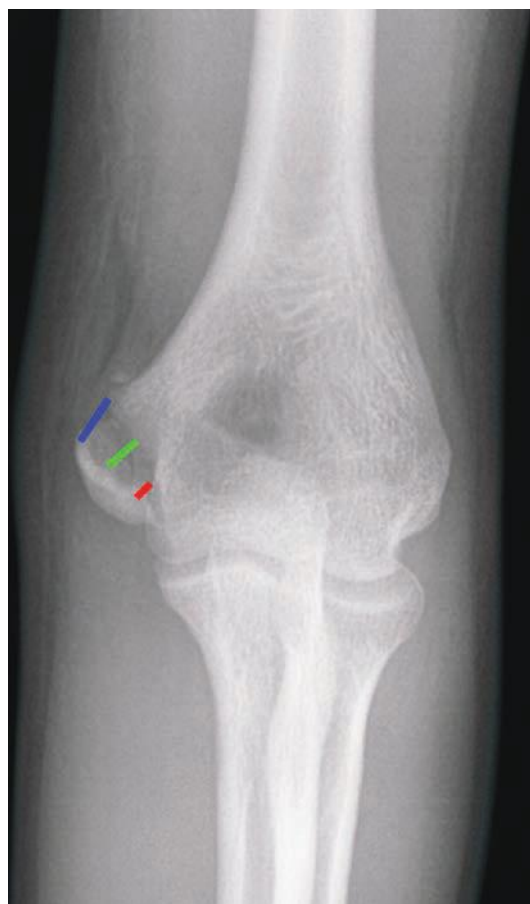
On anteroposterior radiograph of a left elbow with a medial epicondylar fracture, there are three different places where displacement could be measured. The red line represents 2 mm of displacement; the green line, 3 mm; and the blue line, 5 mm. (From Pappas N, Lawrence JT, Donegan D, et al. Intraobserver and interobserver agreement in the measurement of displaced humeral medial epicondyle fractures in children. *J Bone Joint Surg Am.* 2010;92:322–327.)
